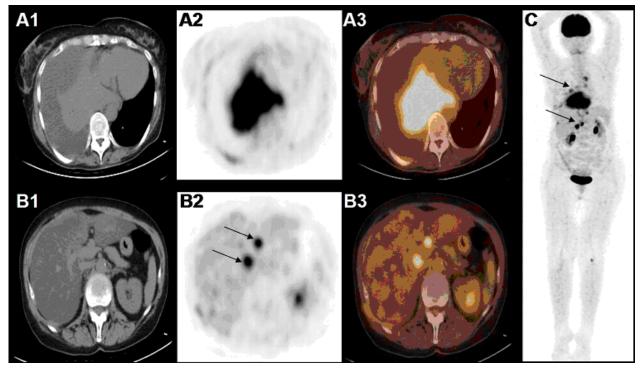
Transverse PET/CT images demonstrate supradiaphragmal (A1/2/3) and infradiaphragmal (B1/2/3) metabolic activity (arrows in B2 point to metabolic active lymph nodes infradiaphragmal). Whole-body maximum intensity projection (MIP) PET image shows metabolically active manifestations in the right lung (arrow), in the mediastinum, and in portal lymph nodes (1C, arrow).
